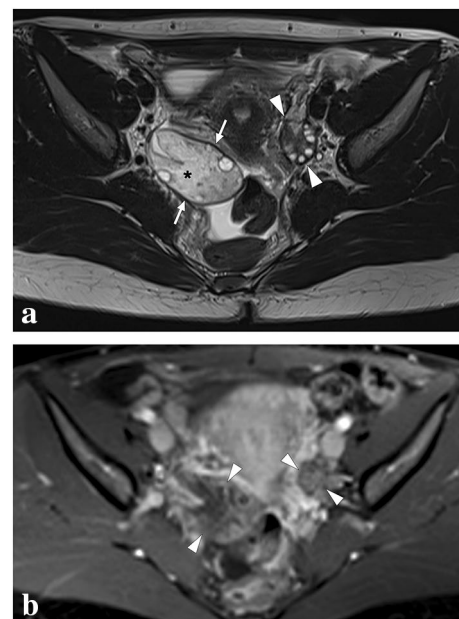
A 30-year-old female patient presented to ER with acute-onset severe abdominal pain in the lower abdomen. US examination revealed an asymmetrically enlarged right ovary (not shown). a Axial plane T2-weighted MR image showed an asymmetrically enlarged right ovary (arrows) compared to its left counterpart (arrowheads). Diffuse stromal T2 hyperintensity due to parenchymal edema (asterisk), peripherally displaced ovarian follicles, T2 hypointense ovarian rim (arrows), and pelvic free fluid are other typical imaging findings for ovarian torsion. b Axial T1W fat-suppressed postcontrast image demonstrated diminished stromal contrast enhancement of the right ovary compared to the left one (arrows). Emergent surgical detorsion was performed immediately after this MR examination
